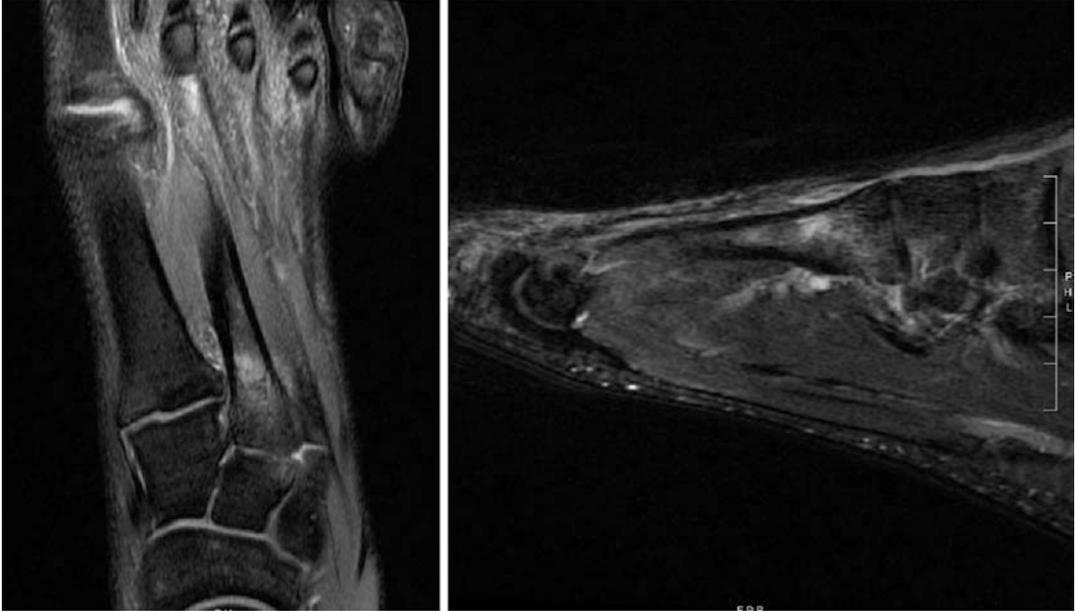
MRI (coronal and sagittal views) demonstrating second metatarsal stress reaction in collegiate basketball player
